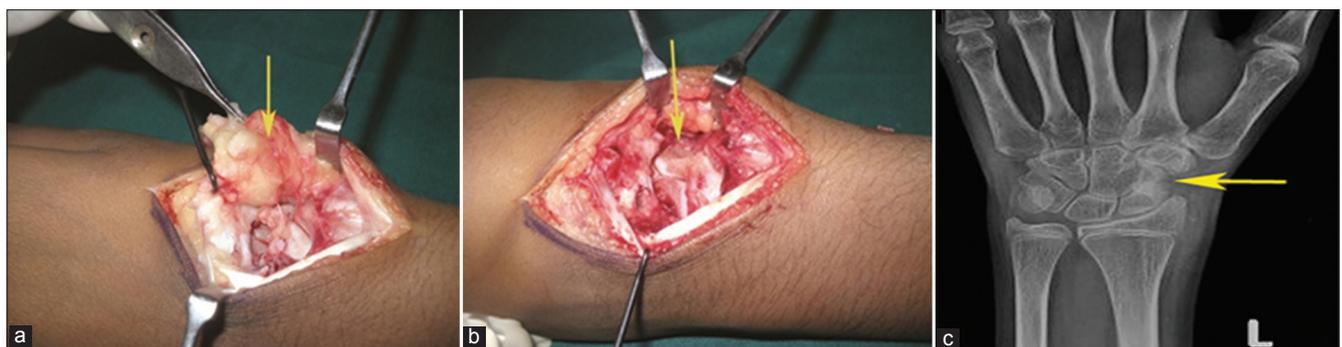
(a, b) Intraoperative picture showing the exuberant synovitis (yellow arrow) and the site of cortical perforation with extruding granulation tissue (yellow arrow). (c) Post-excision radiograph of wrist (anteroposterior view) Yellow arrow showing excised part
